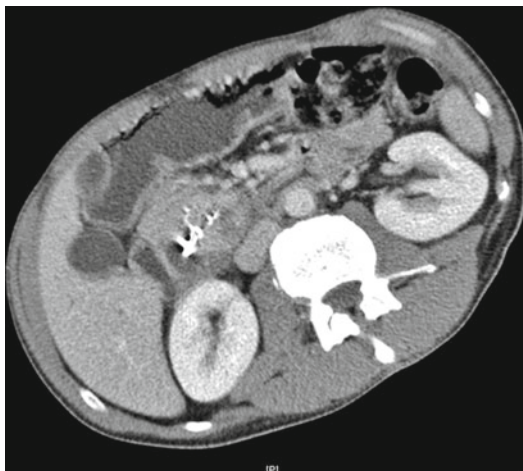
High-resolution CT scan, hydro technique with 30° right-sided position of the patient showing an inflammatory head mass with calcifications as a typical finding in CP patients
